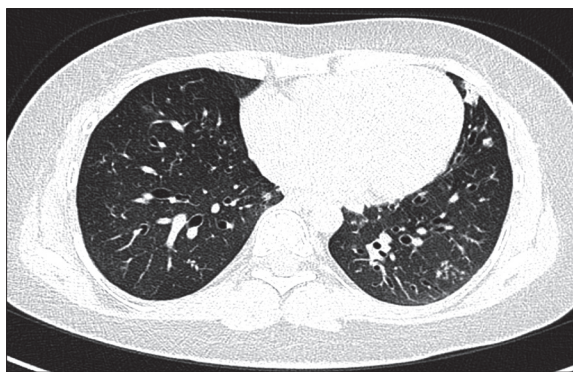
Axial CT scan of the chest, pulmonary window. The same patient, follow-up examination. Bronchiectasis.
